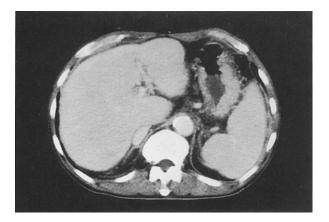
In the portal phase of dynamic CT, the entire liver was homogeneously enhanced.
